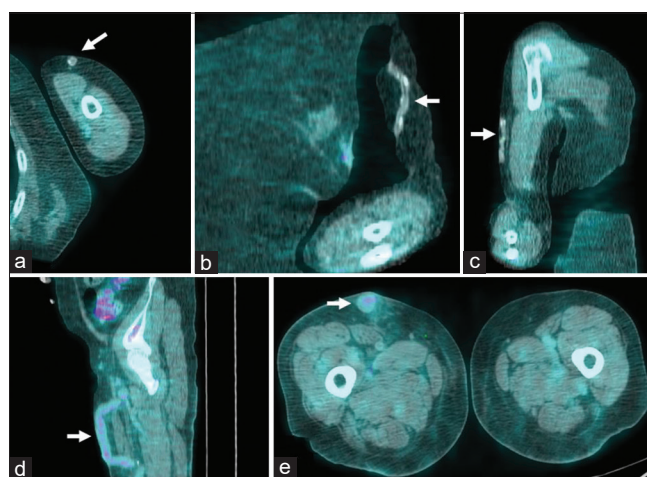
Axial (a), coronal (b), and sagittal (c) fused positron emission tomography/computed tomography images demonstrating no abnormal fluorodeoxyglucose activity at the abandoned left upper arm vascular graft (arrow). Sagittal (d) and axial (e) fused positron emission tomography/computed tomography images of the right thigh vascular graft (arrow) demonstrating physiologic blood pool activity
